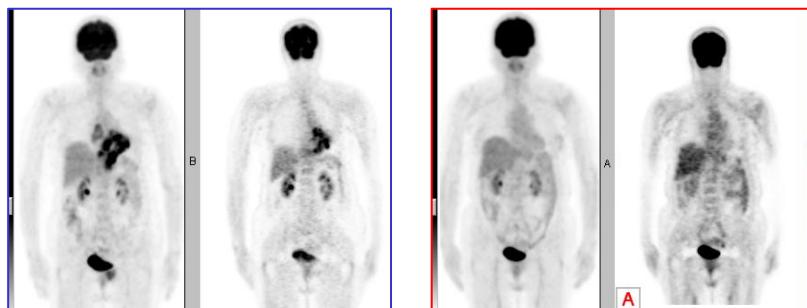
Basal FDG (left): Hypermetabolic mass in posterior toraco-abdominal region concordant with malignant tumoral activity ($SUV_{max}:24$) as well as in two sites in skeleton. FDG control (right) performed 3 months later using GLIVEC® demonstrated: total lesions regression.
